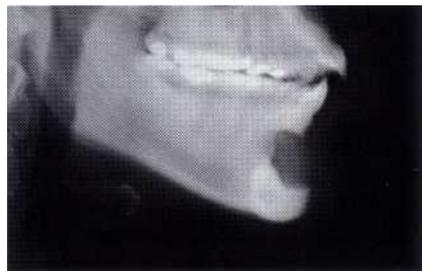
Cephalogram/orthopantomogram showing resorption of the lateral mandibular cortex adjacent to a Silastic chin implant.
